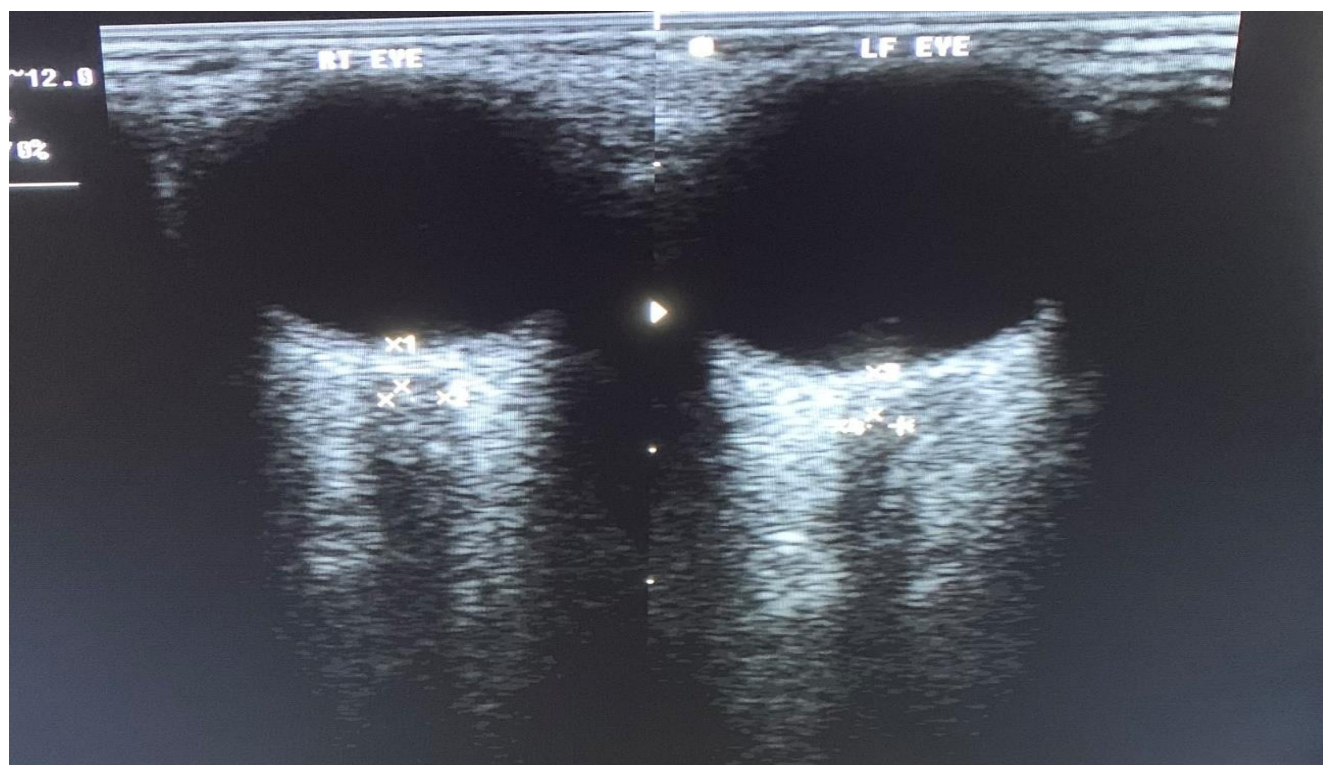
Fig i. Ocular sonogram of the right and left eyes of a 14-year-old male Subject.
